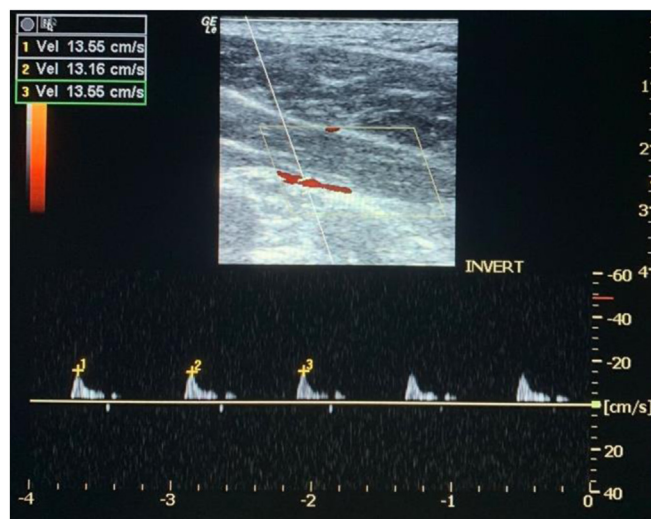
Method of measuring the peak velocity in the dorsal scapular artery in the long-axis pulse Doppler ultrasound image.
